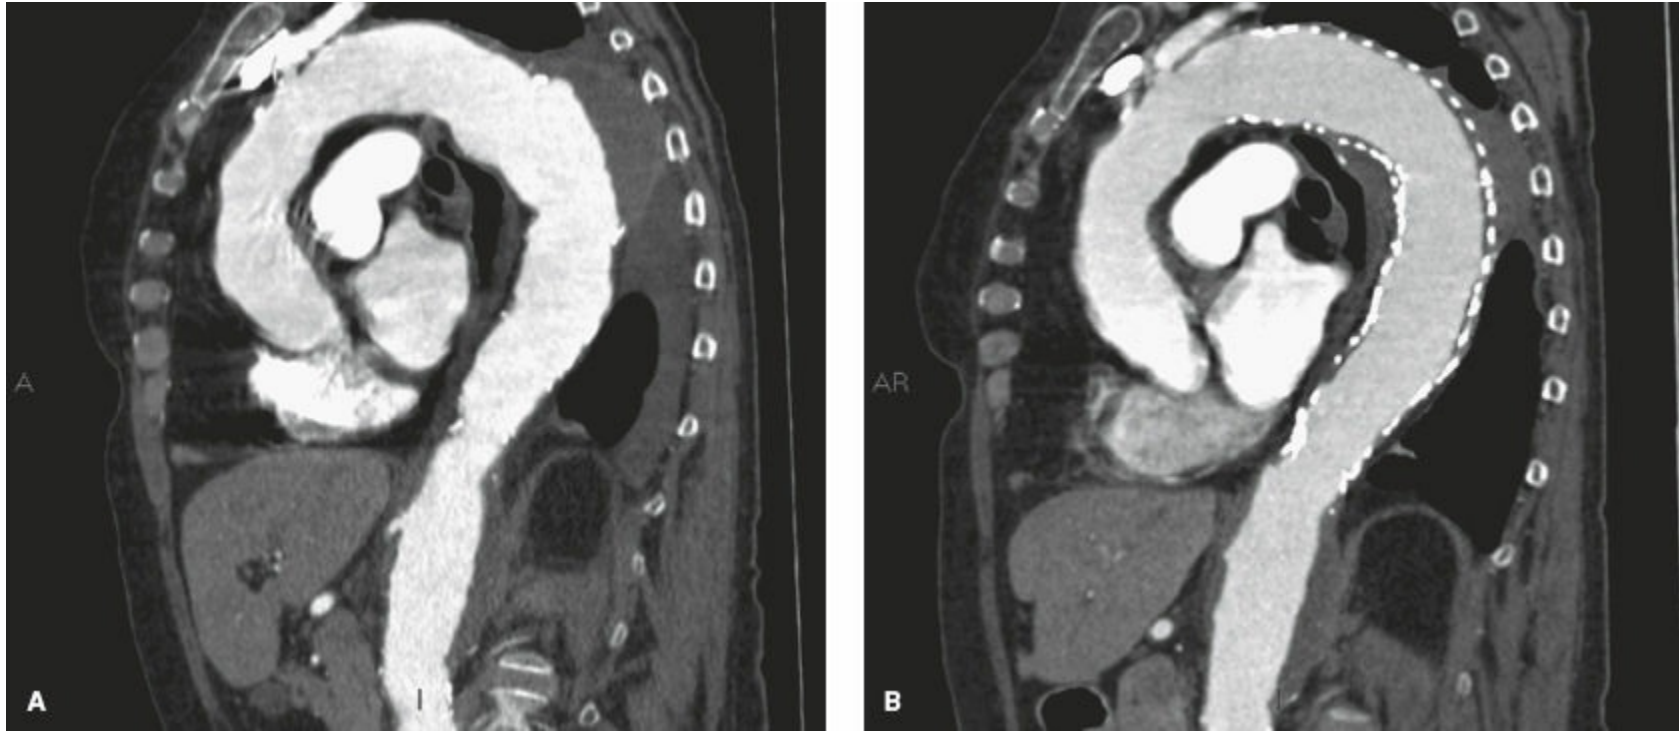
Reconstruction of a CT scan in a patient with a descending thoracic aneurysm (A) prior to repair, and (B) after endovascular stent graft repair showing successful exclusion of the aneurysm sac.
